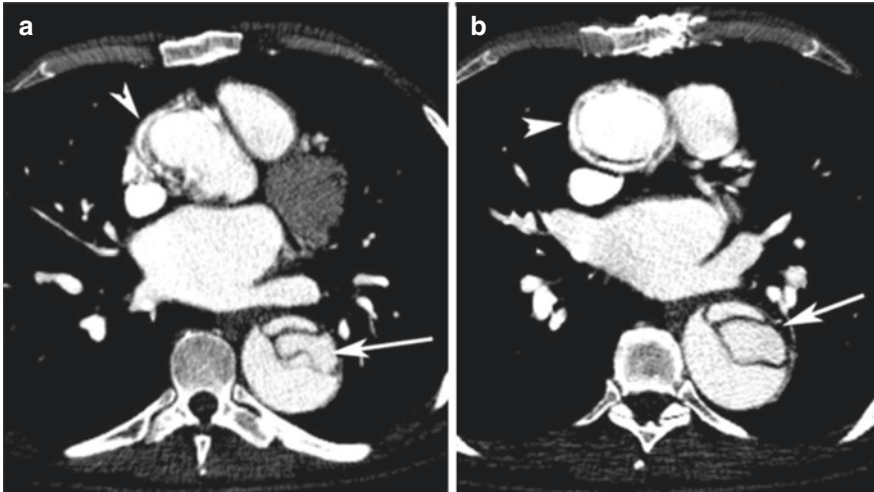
Axial postcontrast computed tomography (CT) in a patient with type A acute aortic dissection (AAD). Axial postcontrast CT images (a and b) showing irregularity of the aortic wall with an intimal flap between the true and false aortic lumens. There is compression of the true lumen of the ascending aorta (white arrowheads, a and b) and of the descending aorta (white arrows, a and b) by expanding false lumen. (Courtesy of the Department of General and Emergency Radiology, A. Cardarelli Hospital, Naples, Italy). Reprinted, with permission, from Bossone E, et al. Acute Aortic Syndromes: Diagnostic and Therapeutic Pathways. *Heart Fail Clin.* 2020;16(3):305–315 [9]
